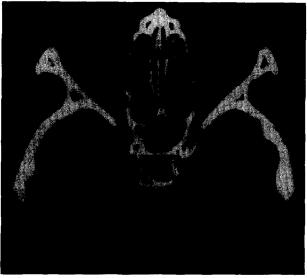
(A: above) Nine diagnostic positions showing esotropia and overaction of right lateral rectus muscle (Case 1). (B: below) CT scan focal enlargement of right lateral rectus muscle (Case 1).
